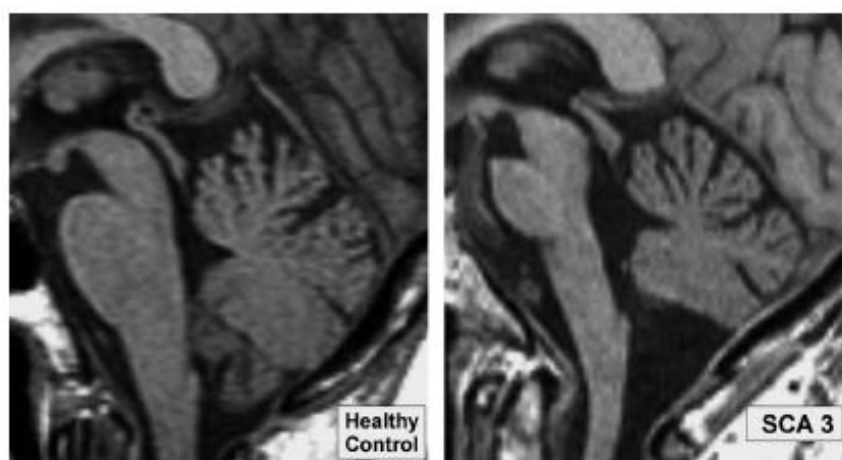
Sagittal T1-weighted images of the brainstem and cerebellum in patients with SCA3 and in a healthy control subject (adapted from Eichler et al, 2011).
